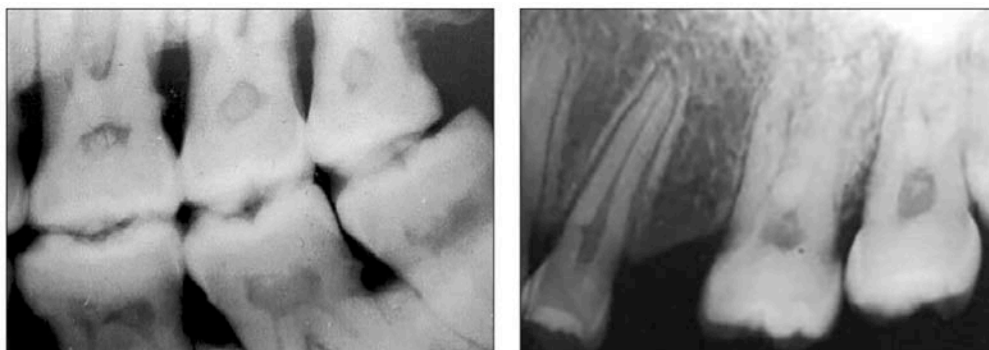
Bitewing and periapical radiographs showing posterior pulp stones of varying sizes.
